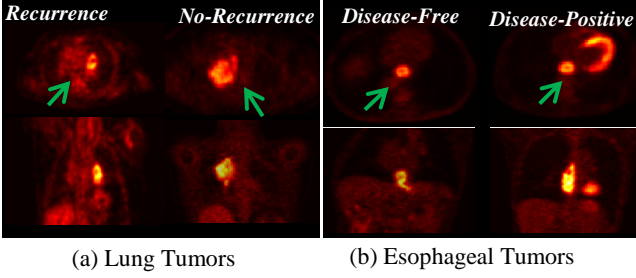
Example tumor uptakes on FDG-PET imaging; (a) recurrence and no-recurrence instances of lung tumor; (b) disease-free and disease-positive instances of esophageal tumor.
